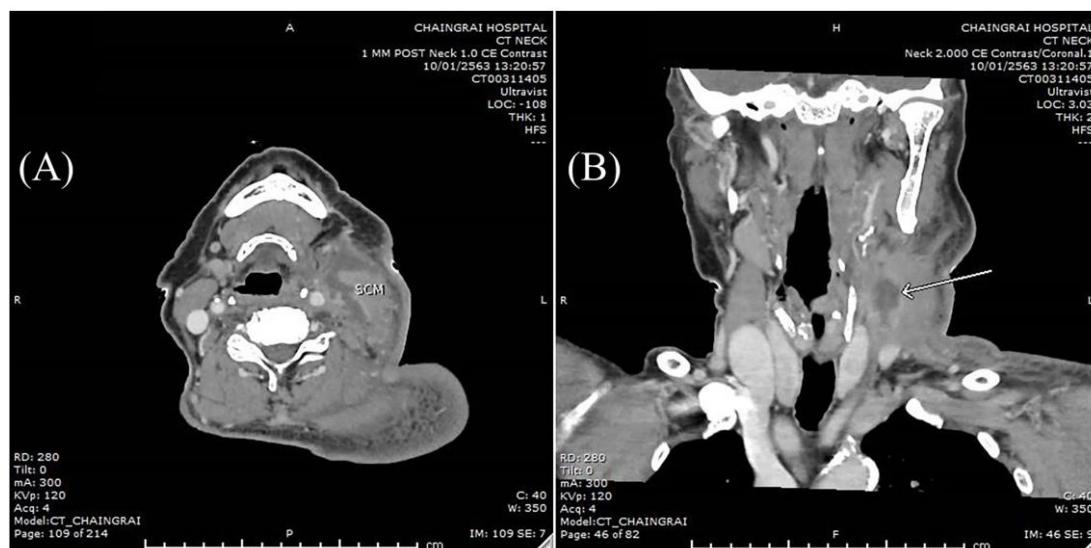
CT imaging showed rim enhancing multi-loculated fluid collection surrounding the enlarged left sternocleidomastoid muscle sized 5.0x2.8x5.0 cm; axial view (A) and coronal view (B)
